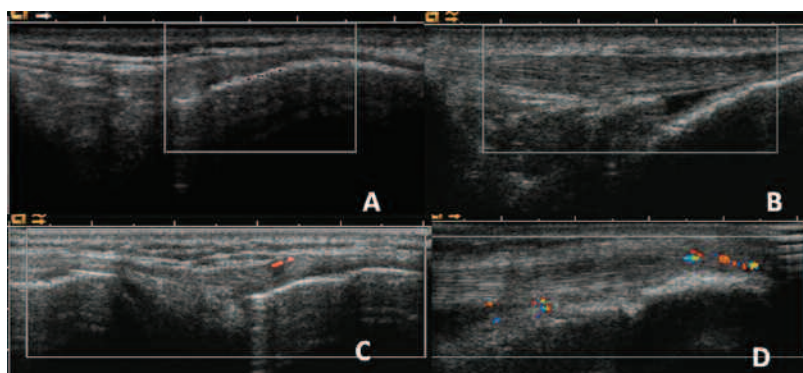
Distinctive patterns of enthesitis detected by color Doppler ultrasonography (CDUS) in patients with ankylosing spondylitis. A. Type A lateral collateral ligament enthesitis; no abnormal findings in both B-mode and CDUS. B. Type B lateral collateral ligament enthesitis; swelling and decreased echogenicity, no color Doppler signals found. C. Type C lateral collateral ligament enthesitis; color Doppler signals were found without abnormal findings in the B-mode. D. Type C patellar ligament enthesitis; swelling, decreased echogenicity, and color Doppler signals were found.
